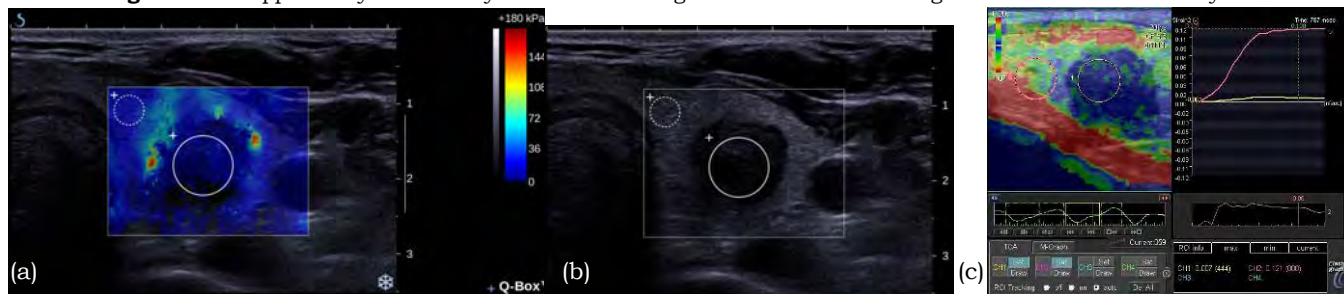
Benign dominant nodule of the left thyroid lobe filled with degenerative changes on pathology examination, in a pt with multinodular goiter, evaluated (a) with SSWE where the nodule is very soft that indicating benign lesion, (b) on B-mode ultrasound where the nodule is deeply hypoechoic, taller than wide, with micro-calcifications indicating a suspicious lesion and (c) evaluated with strain elastography qualitatively and quantitatively where the lesion presents as very hard – more than 17 times harder than surrounding thyroid tissue (strain ratio = 17.28) that strongly indicates malignant lesion.
